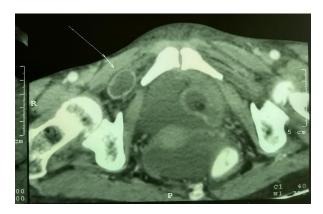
MRI image showing the small bowel loop descending into the right obturator canal anterior to the obturator externus muscle.
